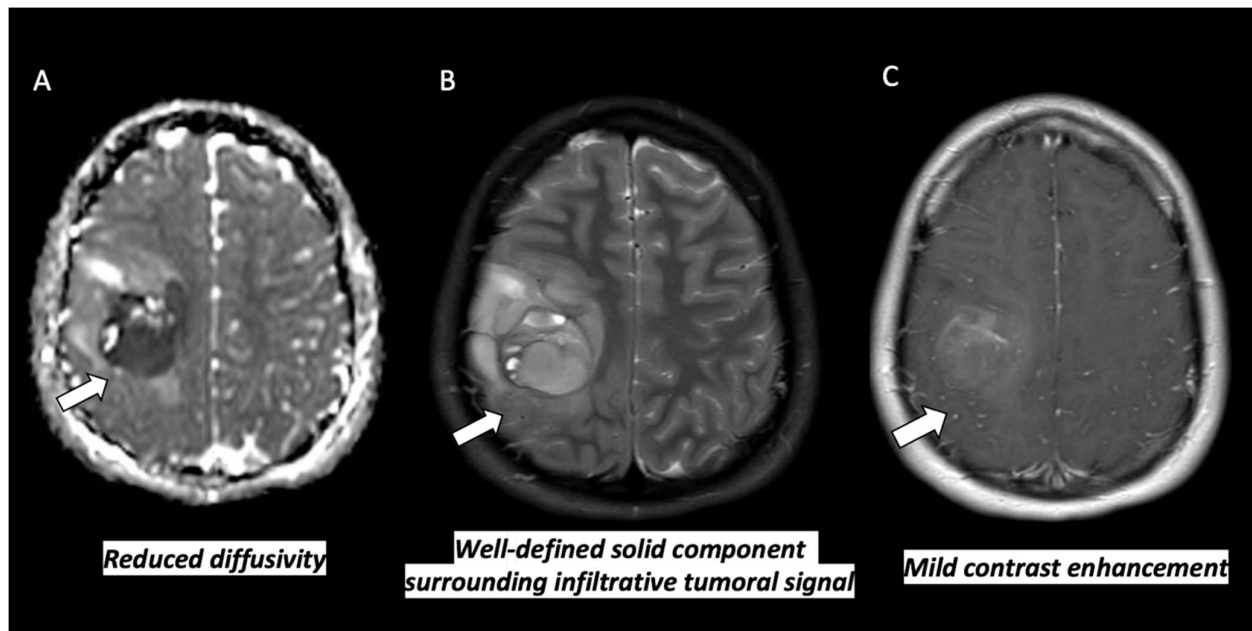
17 years old with *H3 G34* mutant tumor. ADC map, T2-weighted, and T1-weighted post contrast axial images of the brain show a well-defined solid, cortically involved tumor in the right parietal lobe (white arrow) with surrounding infiltrative tumoral signal involving the overlying cortex.
